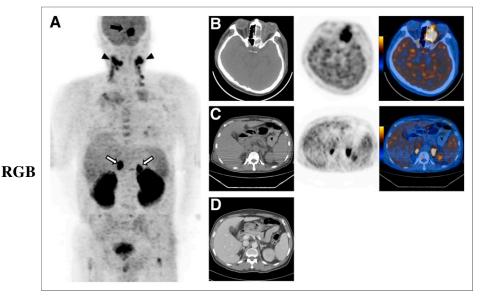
A 60-y-old man with newly diagnosed nasal-type NK/T-cell lymphoma underwent ¹⁸F-FDG PET/CT scan (A–C) and enhanced CT scan (D) for initial staging. Maximum-intensity-projection image (A) shows hypermetabolic lesions in left ethmoid sinus (arrow), both cervical lymphatic chains (arrowhead), and both suprarenal areas (empty arrow). Transaxial images of ¹⁸F-FDG PET/CT scan shows ¹⁸F-FDG-avid mass in left ethmoid sinus (B). ¹⁸F-FDG PET/CT scan showing intense ¹⁸F-FDG uptake in both adrenal glands, suggesting malignancy (C). However, enhanced CT scan shows only mild nodular thickening in both adrenal glands (D). Finally, after obtaining PET/CT scan, stage was changed from II to IV. After 4 cycles of chemotherapy, follow-up ¹⁸F-FDG PET/CT scan showed normalized ¹⁸F-FDG uptake in both adrenal glands.
